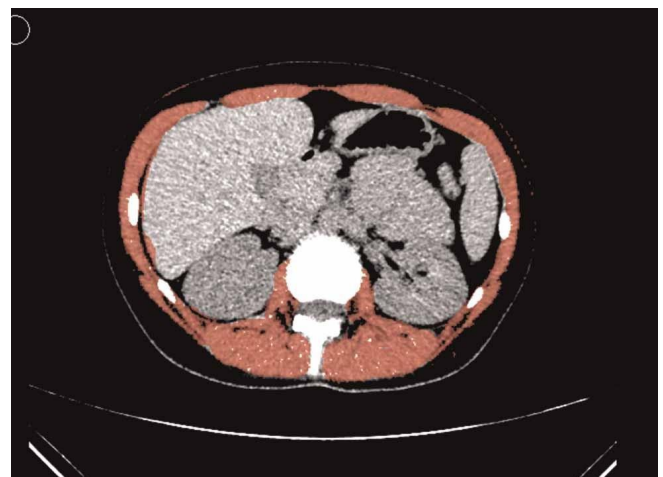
A 60-year-old man with sarcopenia. Computed tomography images extending inferiorly from L3 were evaluated automatically. After application of a predefined Hounsfield unit threshold, the boundaries were corrected manually when necessary.
